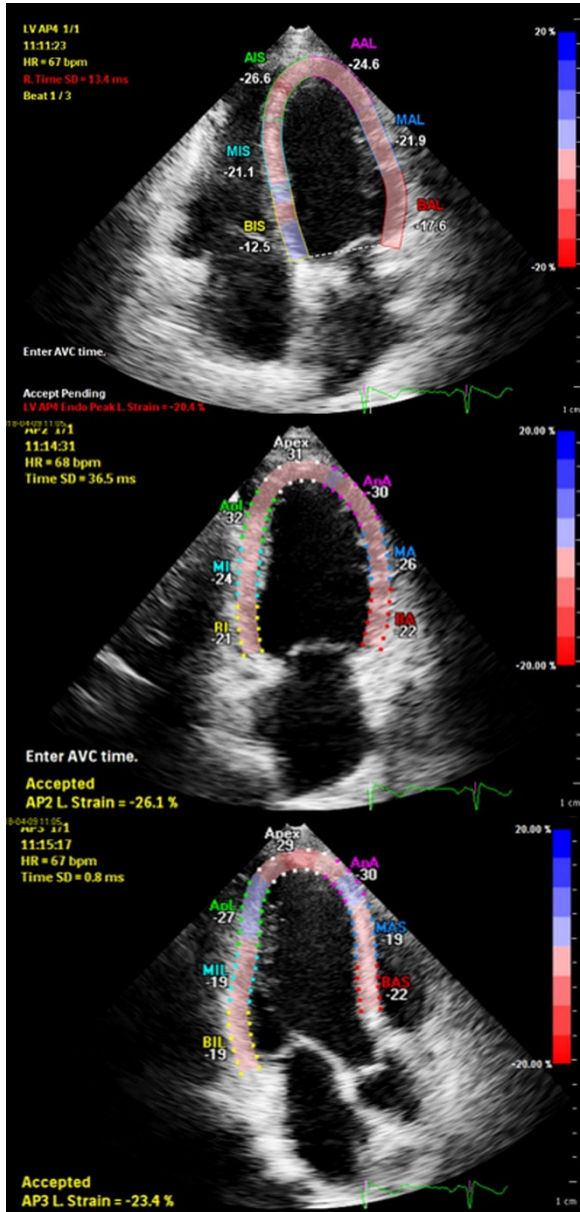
Longitudinal strain measurements obtained from apical 4-, 2- and 3- chamber view.
